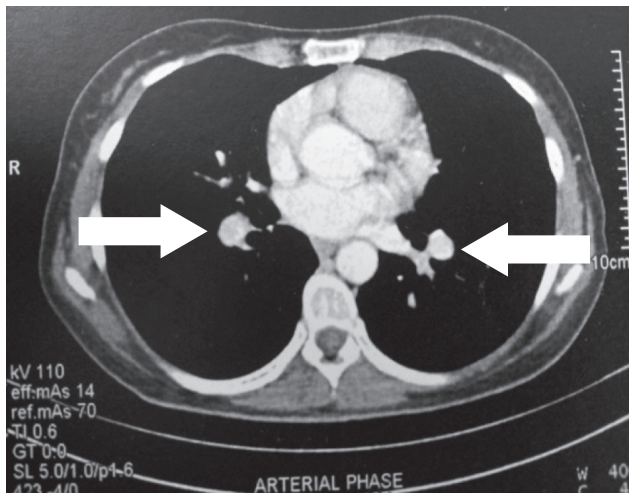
Computed tomography pulmonary angiography shows bilateral pulmonary emboli (arrows).
